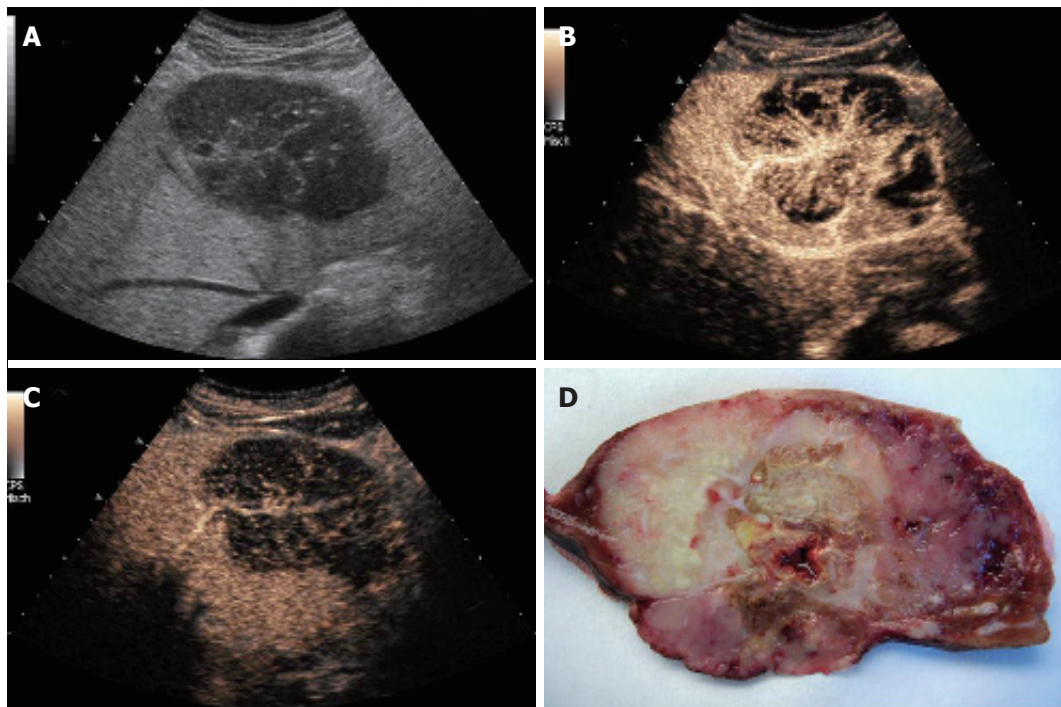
Patient 1: Osteoclastic giant cell tumor of the liver: A: B-mode sonography (HDI 5000, Philips), contrast sonography during the B: arterial and C: portal phase (Siemens); D: resected tumor: cut surface shows distinct tumor areas with necrotic and hemorrhagic regions.
